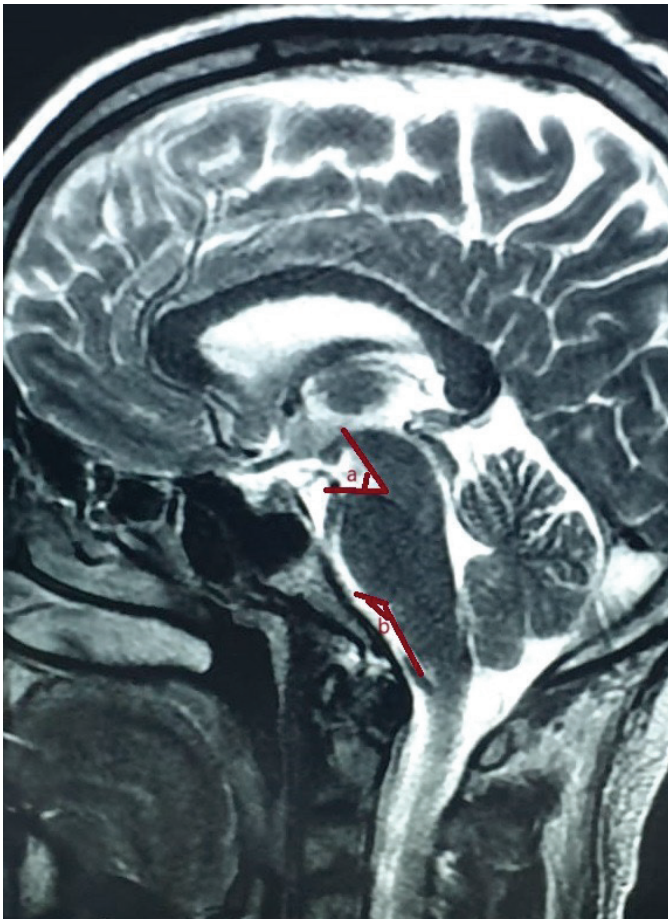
Sagittal magnetic resonance imaging (MRI) demonstrating the measurement of the pontomesencephalic angle (a) and the pontomedullary angle (b).
